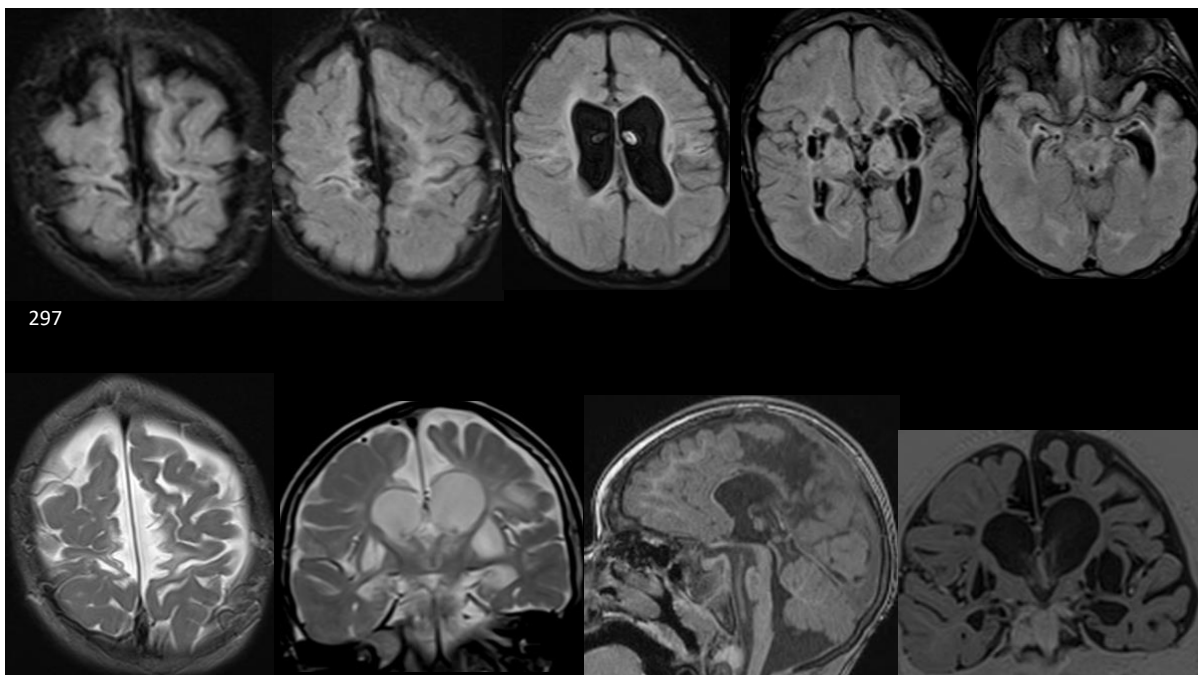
Collage of MRI images obtained for patient 297
